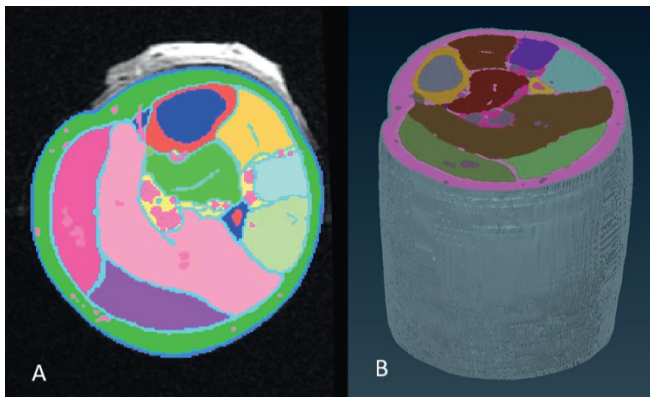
Digital 3D model from MR images: A Segmentation of tissues in Mimics 20.0 (Materialise, Belgium), top slice displayed, B: Surface model in ANSA (BETA CAE Systems, Switzerland) from STL-files created in 3-Matic (Materialise, Belgium).
